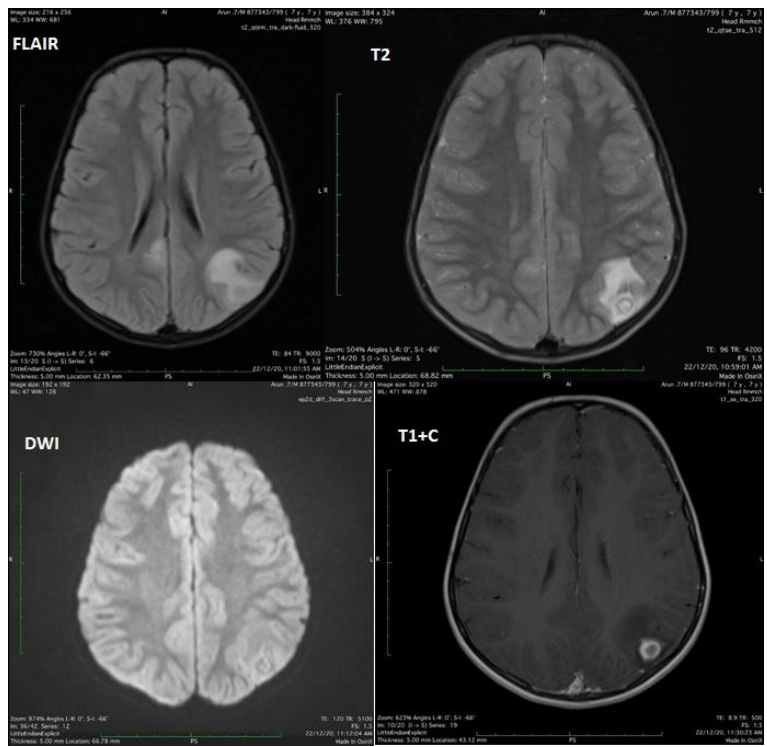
MRI images depicting a case of tuberculoma in left parietal lobe
